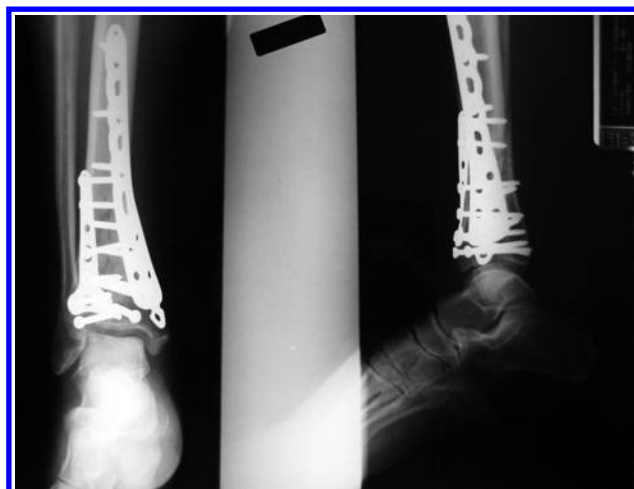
Radiographs of the ankle of patient 1 showing 18 metal implants.
